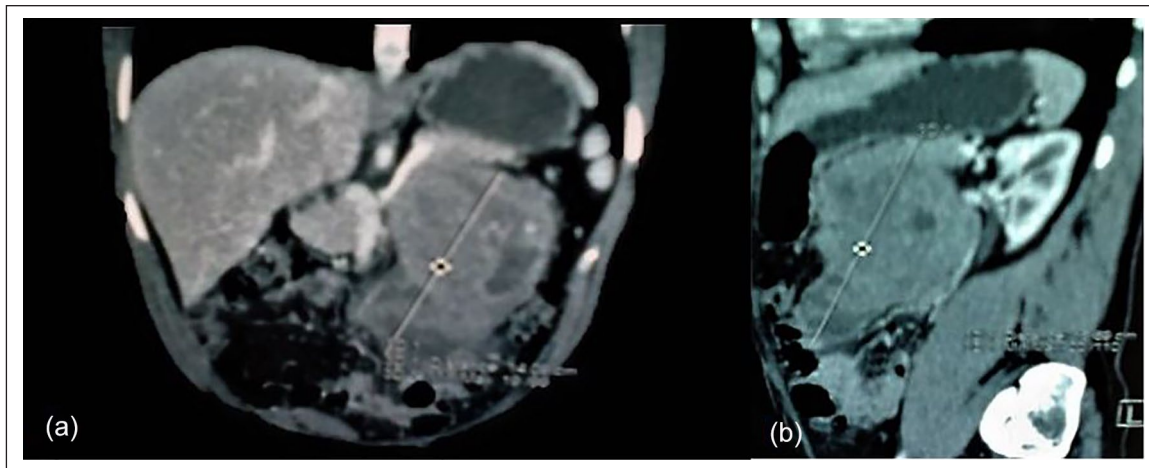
(a) Cross-section, and (b) sagittal section CT scan showing a large, solid, and heterogeneous mass located on the tail of the pancreas. This mass was enhanced after the injection of the contrast agent.
